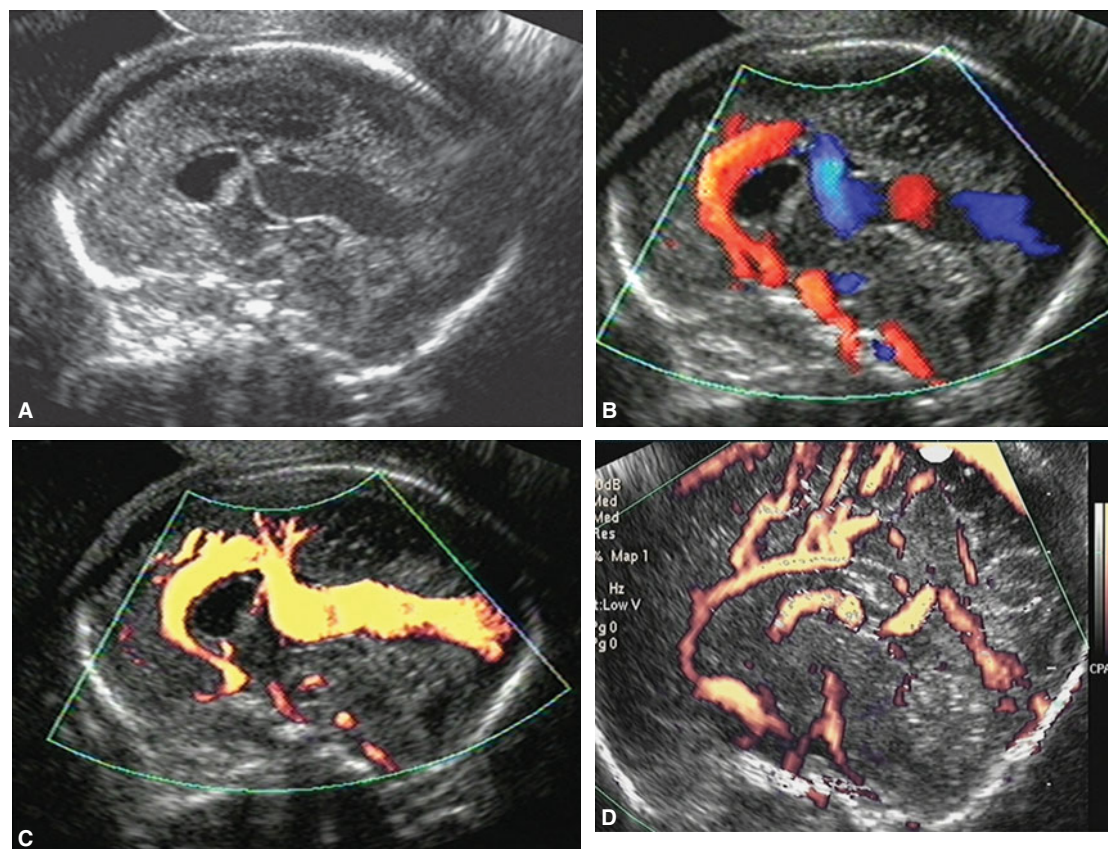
Aneurysm of the vein of Galen at 22 postmenstrual weeks. (A) Two-dimensional (2D) grayscale median plane. (B) 2D color Doppler median plane. (C) 2D power Doppler median plane. (D) 2D power Doppler median plane of a normal vascular pattern for comparison.
